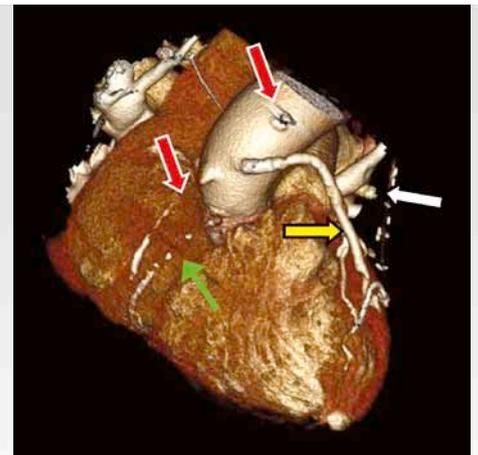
Single volume 320-row CTA providing an immediate overview of anatomy and patency of coronary artery bypass grafts and native vessels in a patient with previous coronary artery bypass grafting. Two occluded venous bypass grafts to the right coronary artery (red arrows), an occluded arterial (LIMA) graft to the left anterior descending coronary artery (white arrow), an occluded right coronary artery (green arrow) and a patent sequential venous graft to the left anterior descending coronary artery and first diagonal branch are observed. Definitions: LIMA: left internal mammary artery
